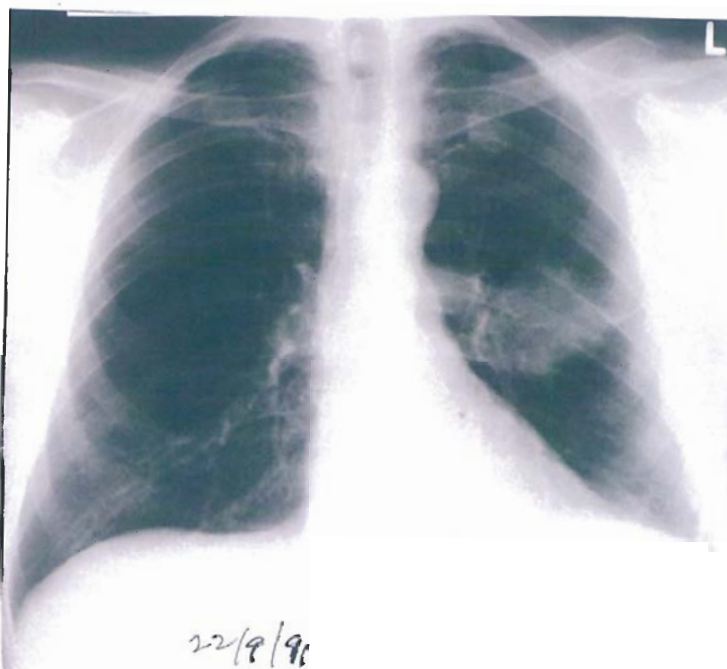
The x-ray appearance on 22 September 1991. His fate is unknown, presumably dead. He was untraceable overseas.
